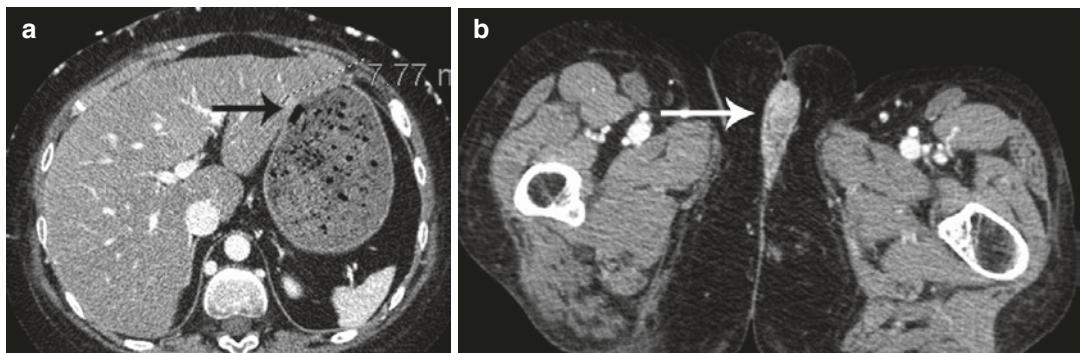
(a) Axial CT image of the abdomen with IV contrast in a 68 year old woman being investigated for an echogenic liver mass incidentally found on US shows an 8 mm hyperdense/hyperenhancing area in the left lobe (arrow) which on follow-up MRI was found to represent focal fat infiltration. (b) CT in the same patient with field
